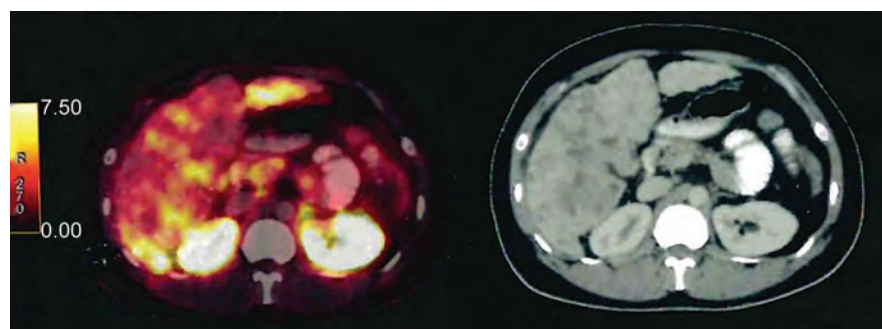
PET and triple phase CT abdomen
